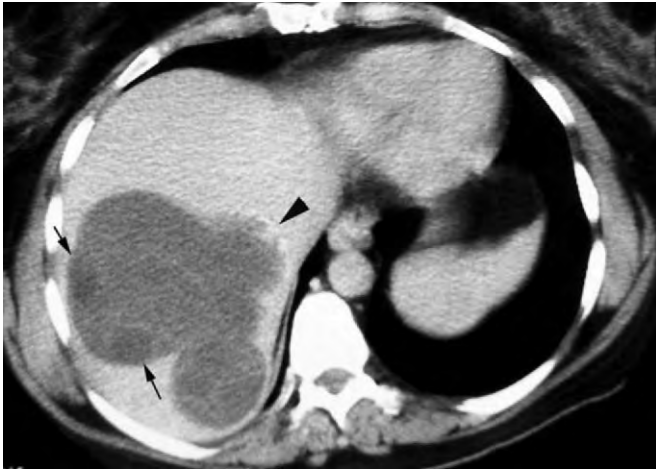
Hydatid cyst. Transverse nonenhanced CT image shows a cystic mass containing several daughter cysts (arrows) and peripheral calcification (arrowhead).
